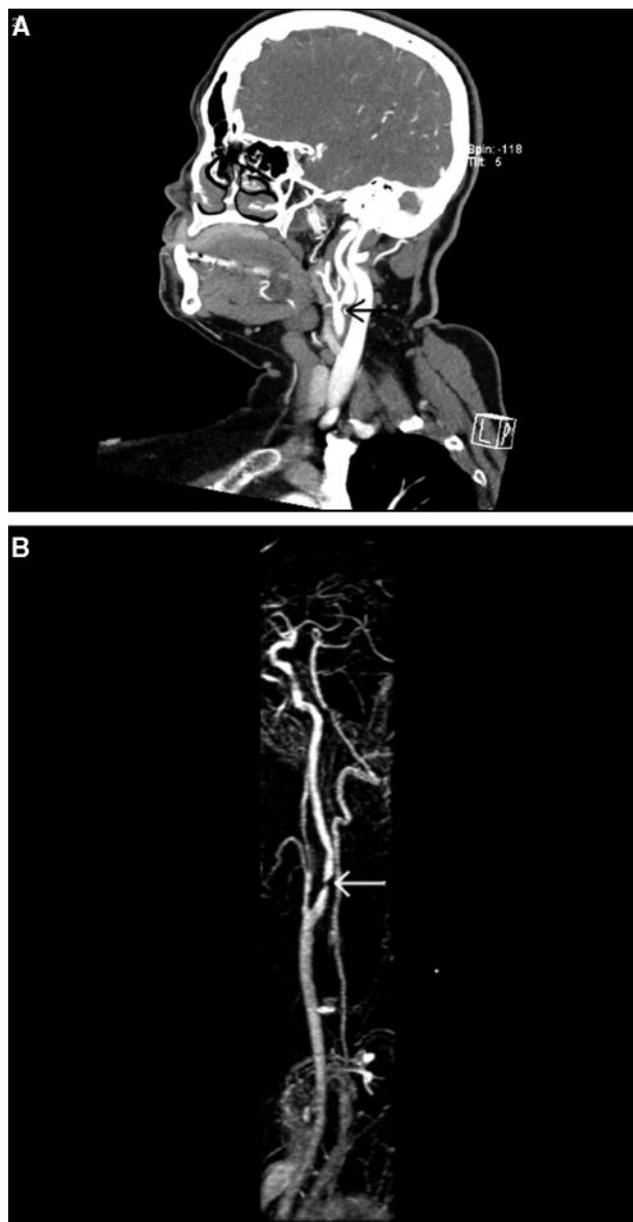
A, Computed tomography angiogram scan of a carotid artery in the neck. B, Magnetic resonance angiogram of the carotid artery. The arrow in each image indicates a blockage.
